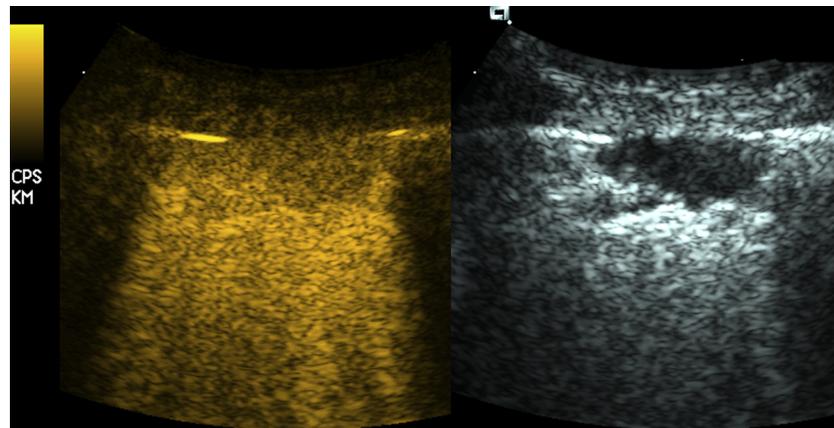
Pulmonary thrombembolism. Because of the loss of surfactant production, the alveolar spaces fill up with fluids within minutes after the thrombembolic accident. B-Mode sonographic imaging reveals a variably hypo-echoic lesion (right). The time frame and certainty of diagnosis can be sometimes improved by contrast-enhanced ultrasound (left).
